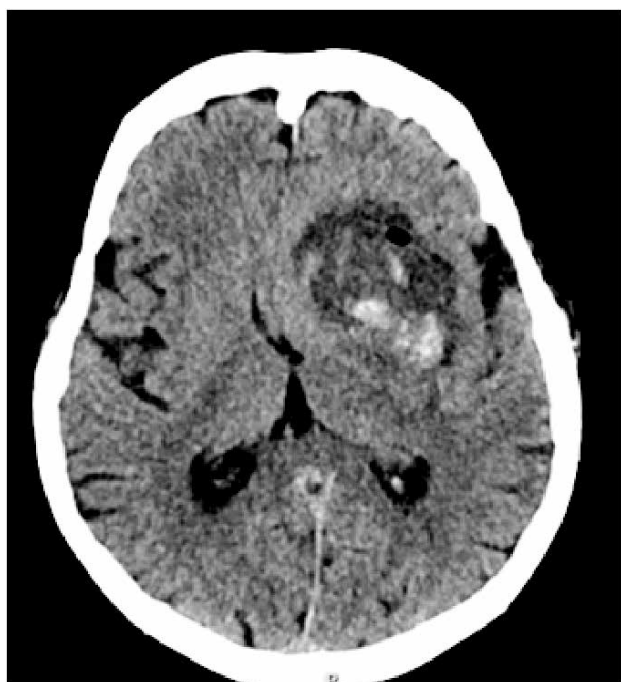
Control CT after navigated (NAVI) biopsy. Post-biopsy changes with gas collections in the lesion area. Stable morphology and mass effect with a 9-10 mm midline shift (05.02.2026).
